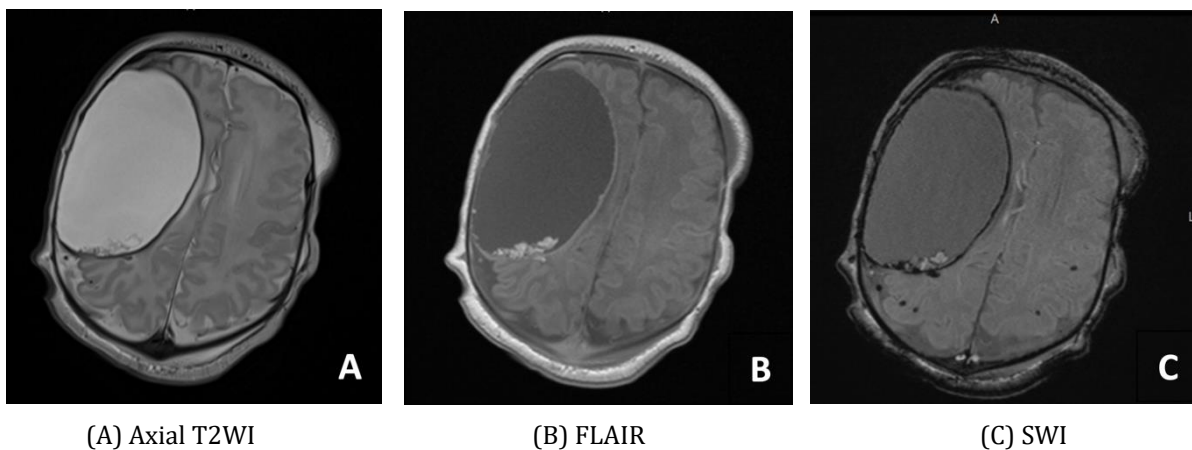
Coagulated blood is seen on the medial aspect of the large right frontoparietal porencephalic cyst, suggestive of intracranial hemorrhaging. This are visualized on (A) Axial T2WI, (B) FLAIR, (C) SWI.
